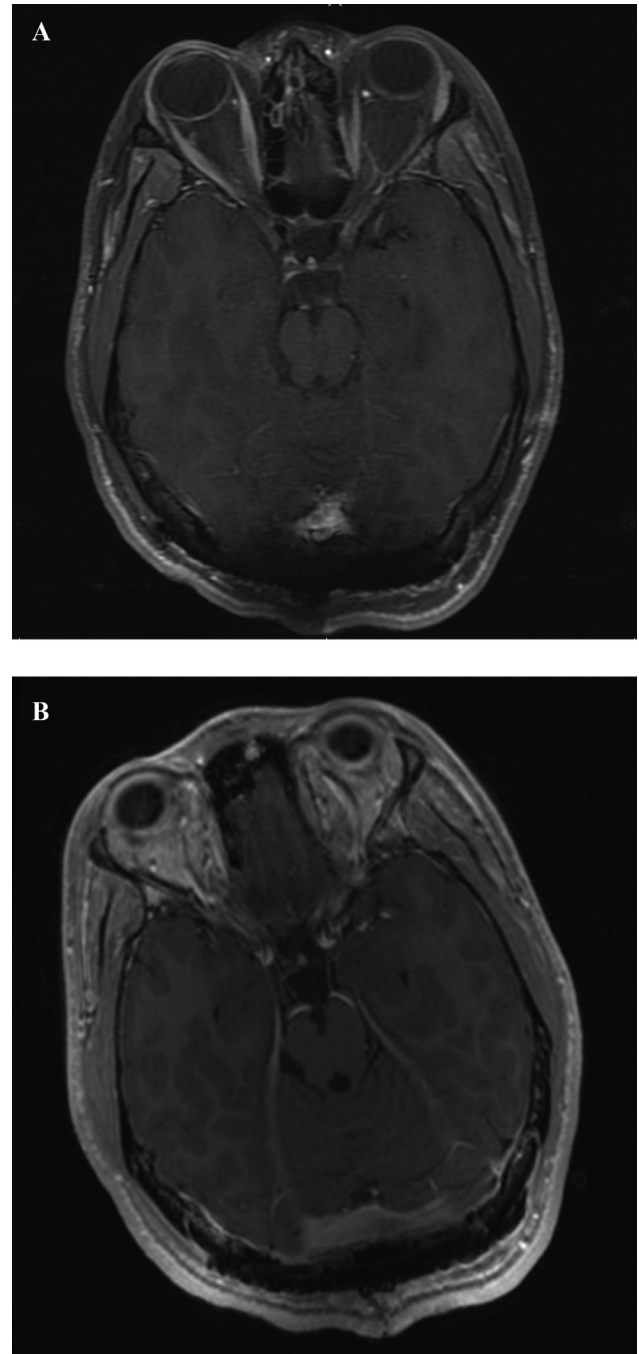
Postoperative MRI. Axial T1-weighted images after IV gadolinium administration (A) thick slice and (B) thin slice images show complete resection of the mass without residual enhancement at the surgical site.
